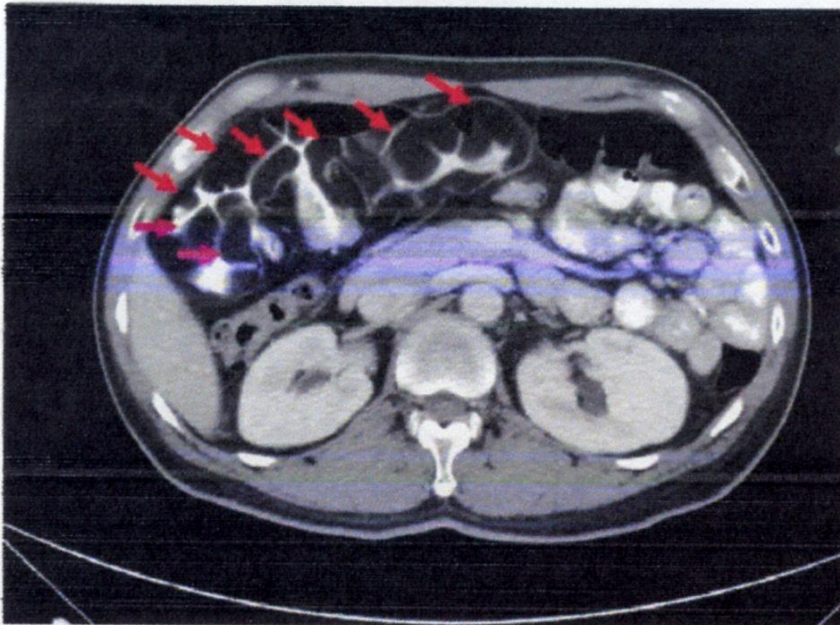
Abdominal computed tomography (transverse view) revealed diffuse and multiple intramural fat density masses (arrows) in the long segment of the small intestine.
